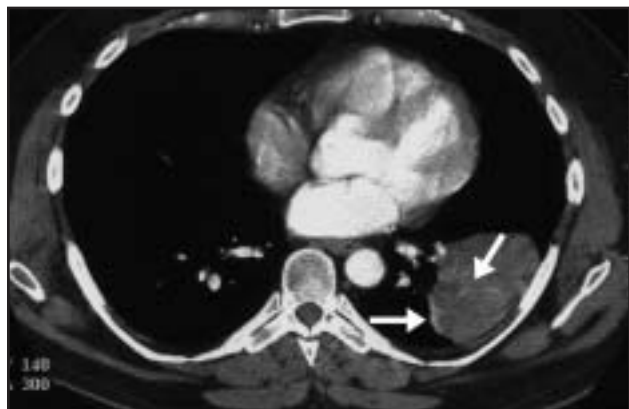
Contrast enhanced axial CT image depicting a smoothly marginated peripheral mass in the left lower hemithorax. The mass is heterogeneous with focal areas of enhancement (arrows).
